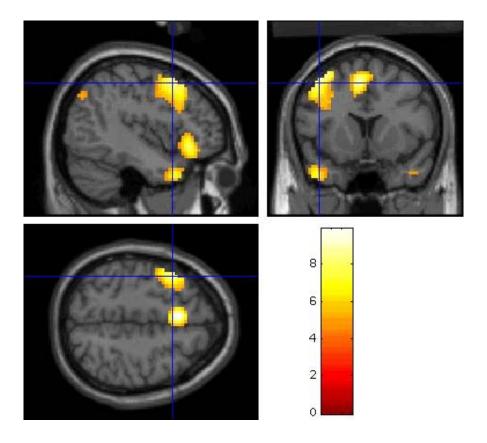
Relative increases in neural activity associated with negative remembrances (compared to rest) superimposed on MRI sections to depict the functional anatomy of the activations and their relationship to the underlying structural anatomy.
